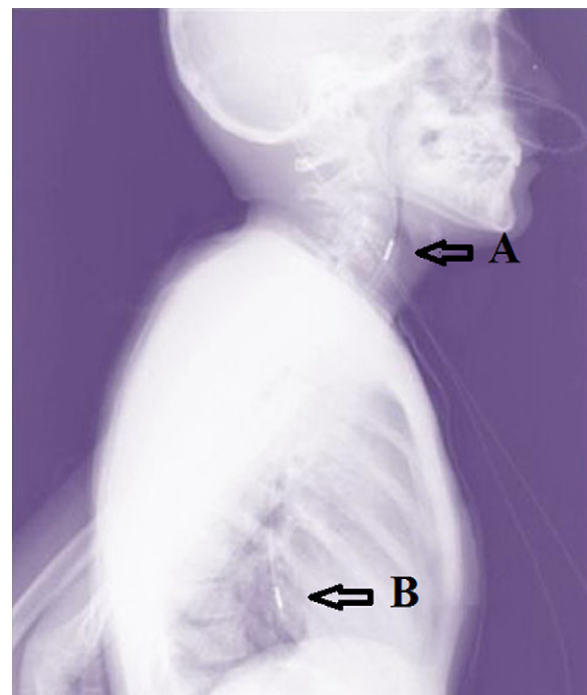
X-ray imaging of the pharyngeal probe (A) and esophageal probe (B).
